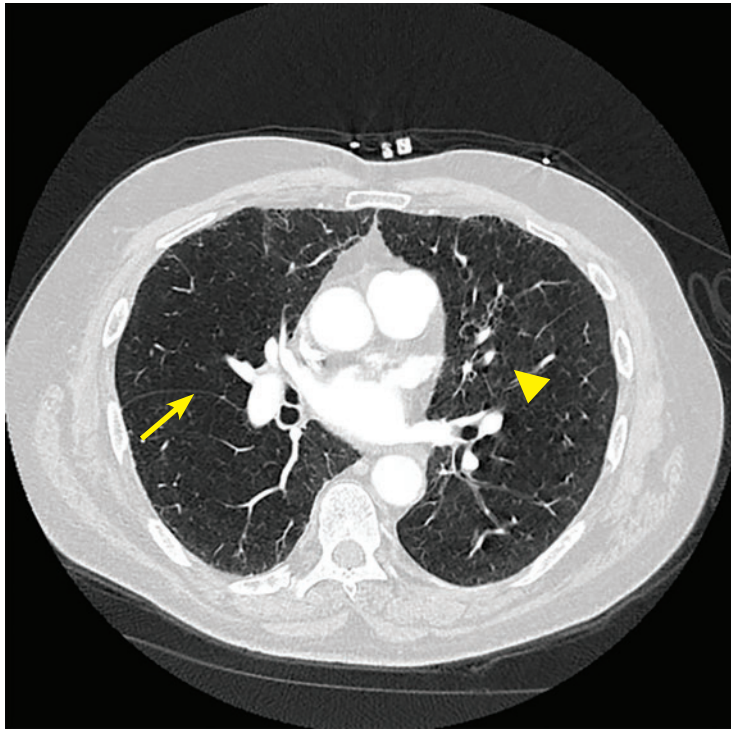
Specialized computed tomography software allows objective quantification of fissure integrity. The arrow indicates a complete fissure, and the arrowhead indicates incomplete fissure. Collateral ventilation is considered highly likely when the fissure is incomplete by > 20% across its span. This is a contraindication to valve therapy.
